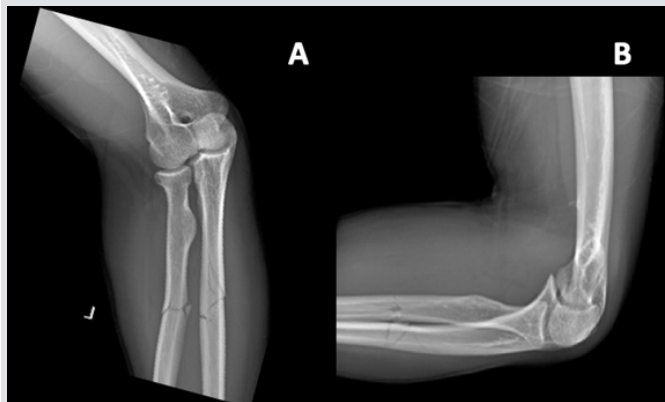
AP (a) and lateral (b) X-rays demonstrate non-displaced fractures in the proximal third of the radius and ulna with minimal comminution.
